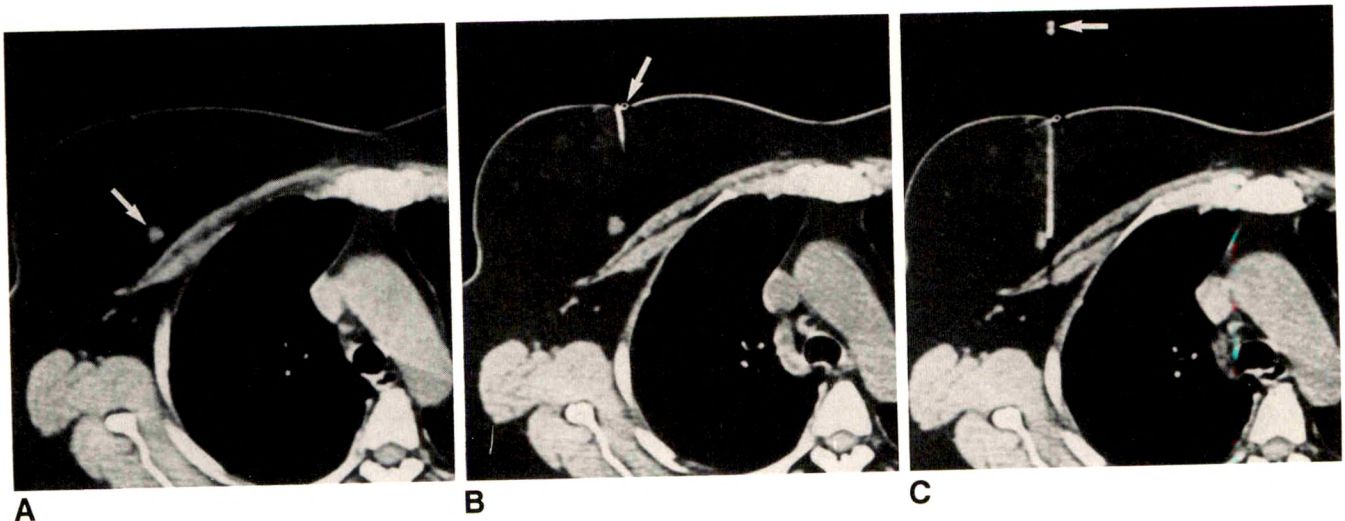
CT-guided localization.
